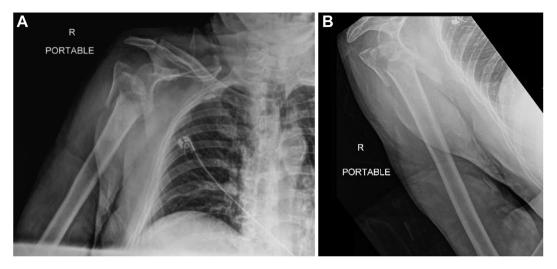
Preoperative x-rays. (A) An AP view of the right shoulder. (B) A lateral view of the right shoulder. AP, anterior posterior.
